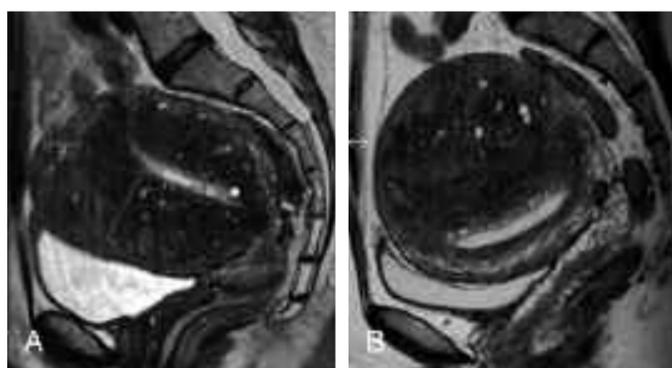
Sagittal T2-weighted MRI of diffuse (a) and focal (b) adenomyosis.
